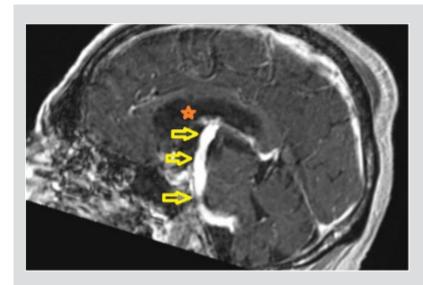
Time-of-flight brain MRI (coronal view) with contrast agent showing dolichoectasia of the basilar artery (yellow arrows) causing dilatation of the ventricular system (orange star)
